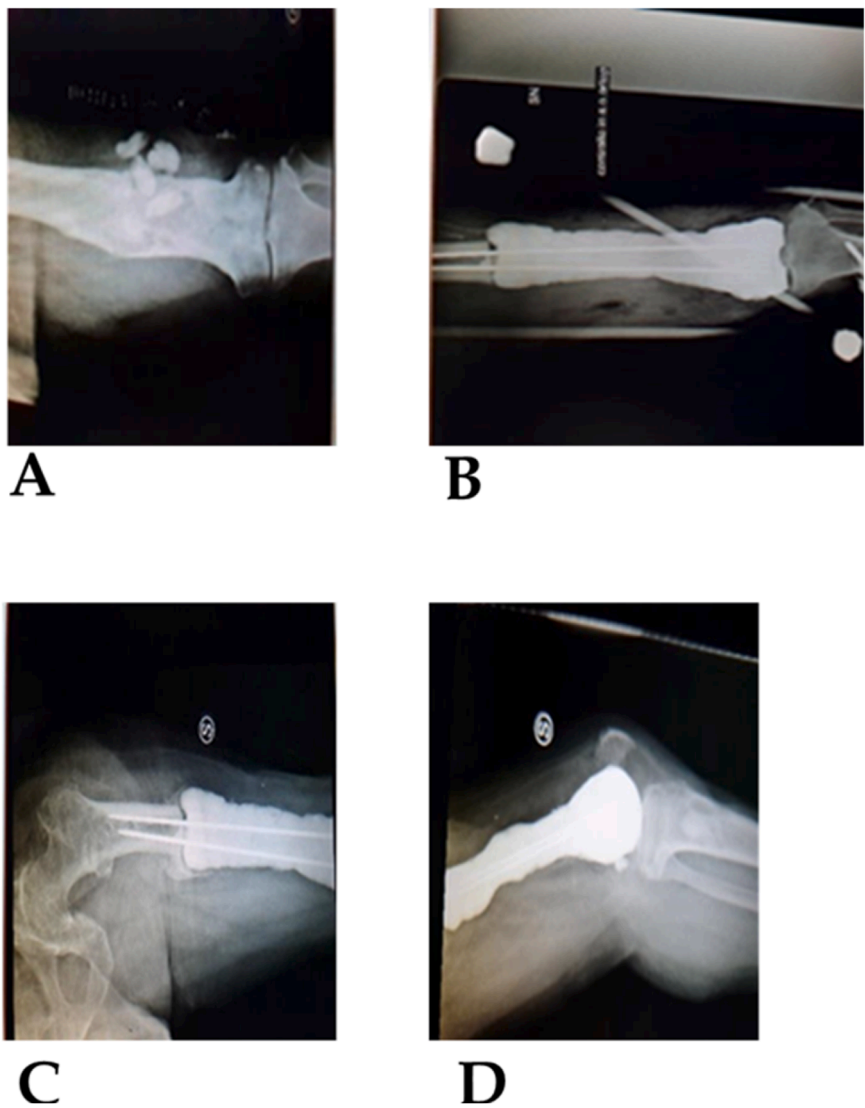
(A): X-ray imaging at the time of initial presentation. (B): Pseudotumoral resection and implantation of an antibiotic-loaded cement spacer with a metallic core, stabilized using a knee-bridging EF. (C): X-ray imaging after 8 months: The patient is ambulatory with knee stiffness. (D): X-ray imaging after 8 months, sagittal projection of the knee.
